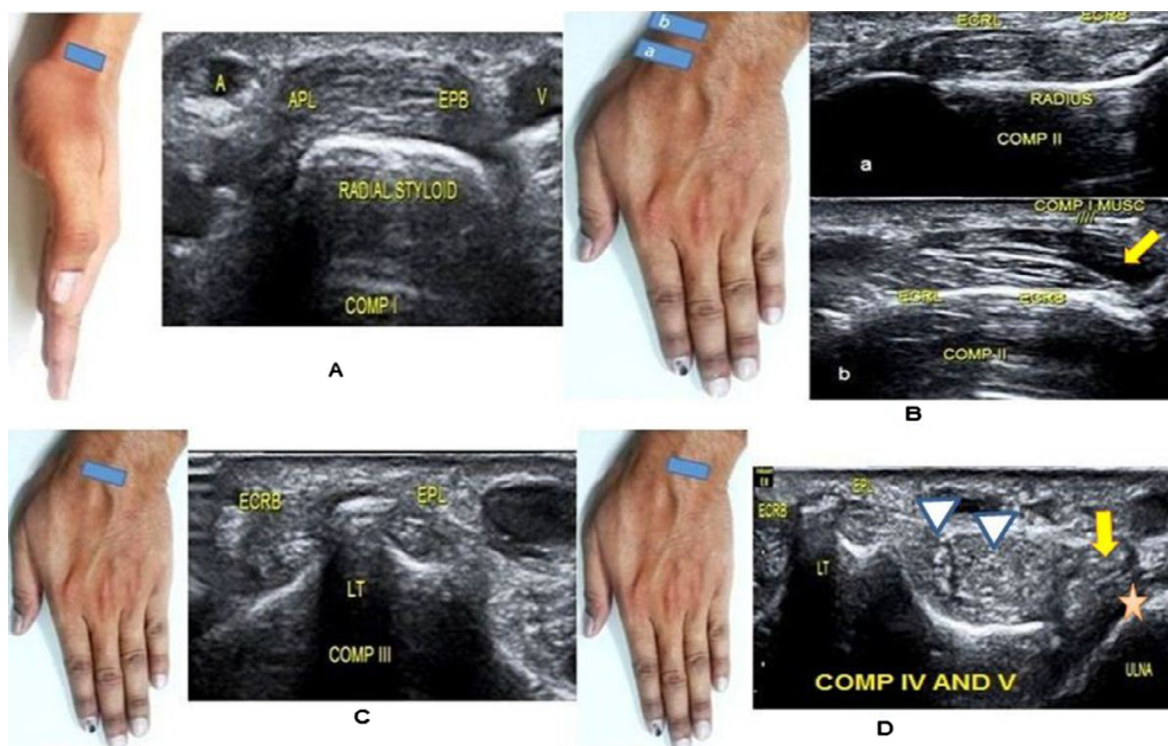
Ultrasound of the dorsal aspect of the wrist demonstrating extensor compartment I (A) containing the abductor pollicis longus (APL) and extensor pollicis brevis (EPB). (A) Radial artery, (V) Cephalic vein. Compartment II (B) containing the extensor carpi radialis longus and brevis (ECRL and ECRB). If the ultrasound probe is moved slightly proximally, crossing of compartment I tendons superficial to the compartment II tendons can be demonstrated (arrow). Compartment III (C) containing the extensor pollicis longus tendon (EPL). Lister tubercle (LT) is the bony landmark separating compartments II and III. Compartments IV and V (D) containing the extensor digitorum communis (arrow heads), extensor indicis, and extensor digiti quinti proprius (arrow). *: ulnar articular cartilage.
